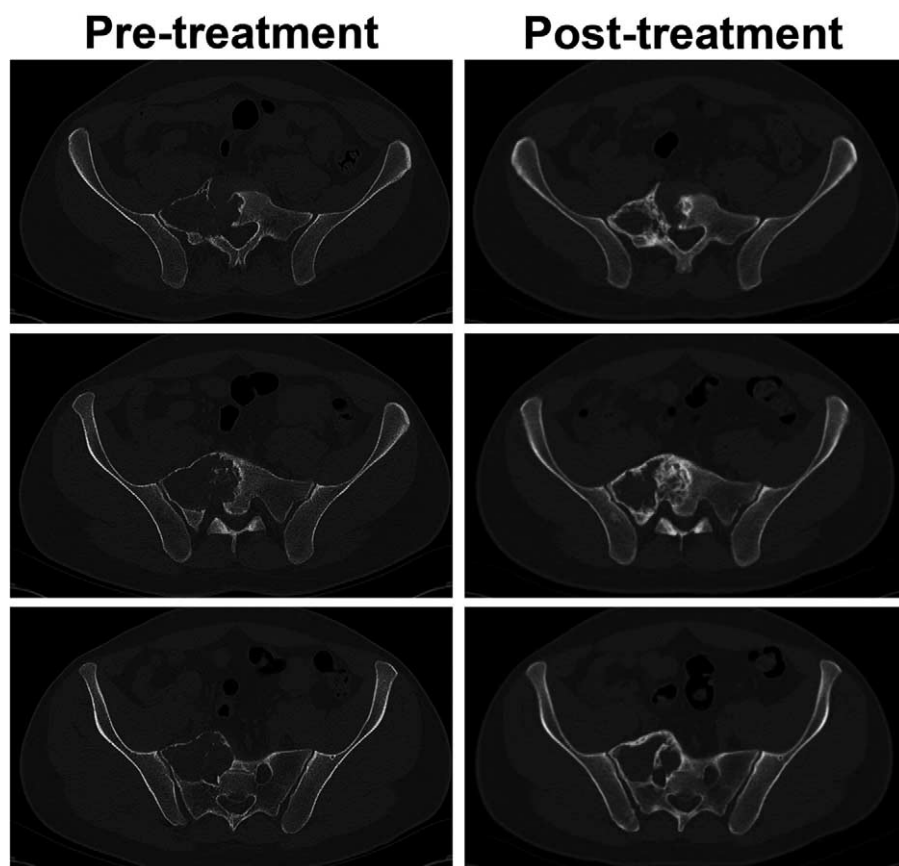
Computed tomographic scans at baseline (left panel) and after 11 months of denosumab treatment (right panel).
